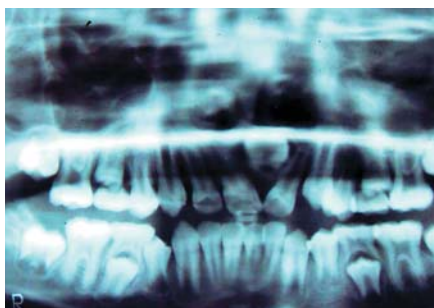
Panoramic radiograph showing impacted permanent maxillary left central incisor
